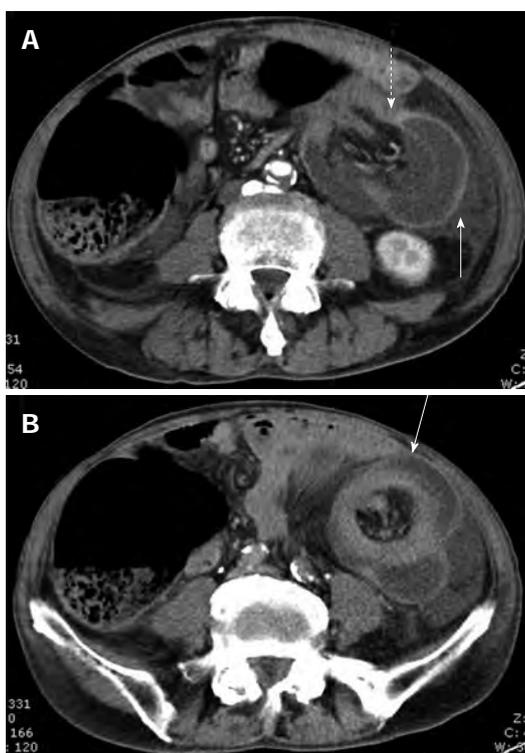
Abdominal computed tomography showing colocolic component of the intussusception (A, dashed arrow), thick-walled descending colon invaginated by transverse colon with mesenteric fat and vessels (A, solid arrow), and the typical "target sign" of colon within colon (B, solid arrow).
